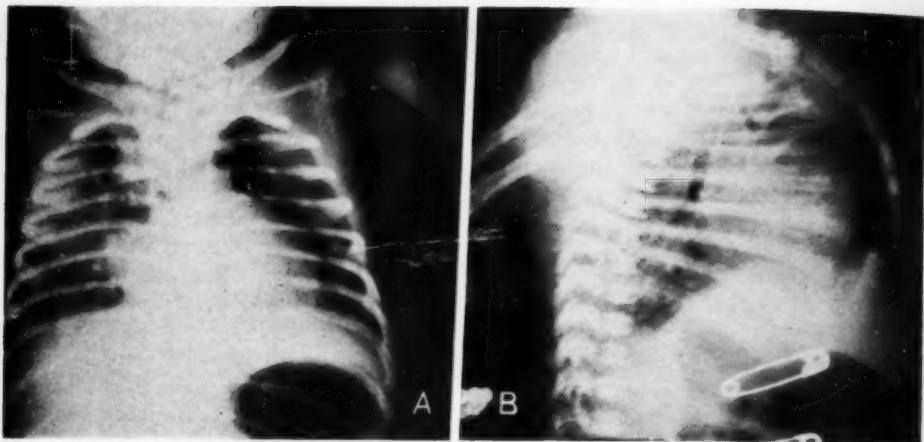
Case 1: A. Roentgenogram 36 hours after birth, showing air in the anterior mediastinum and between the layers of the cervical fascia on both sides. B. Lateral view, showing air in the anterior and superior mediastinum; the heart is compressed and displaced posteriorly.
